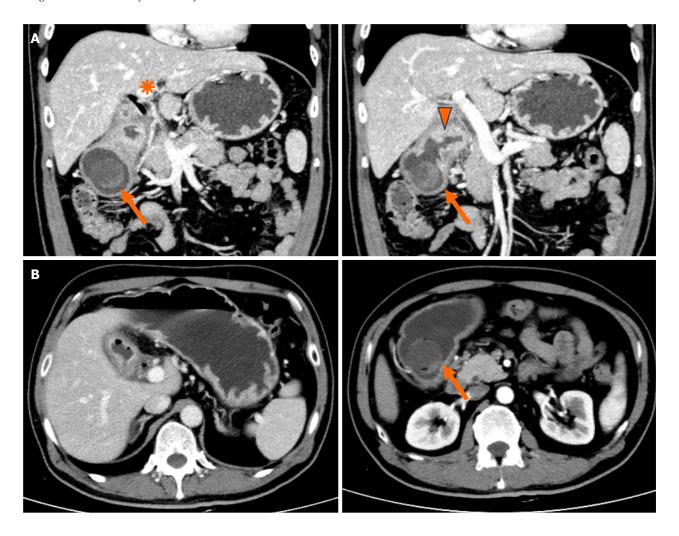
Computed tomography. A: Coronal computed tomography (CT) scan showing pneumobilia (asterisk) and a cholecystogastric fistula (arrowhead) with a large gallstone in the gastric antrum (arrows); B: Axial CT scan showing chronic cholecystitis with a gas-filled gallbladder and gallstones in the gastric antrum (arrow).
